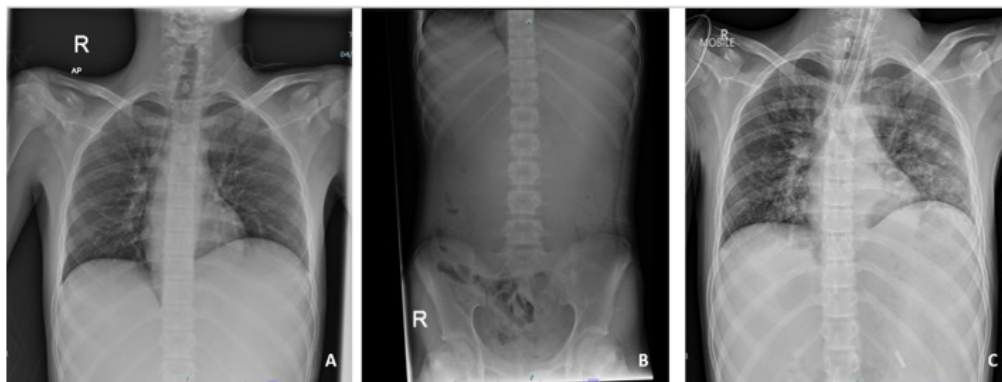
(A) Chest radiograph revealed an elevated left hemidiaphragm with absent of gastric bubble; (B) Abdominal radiograph revealed a paucity of small bowel gases that suggest proximal intestinal obstruction; (C) Chest radiograph taken post-intubation revealed bilateral alveolar opacities after the patient aspirated
